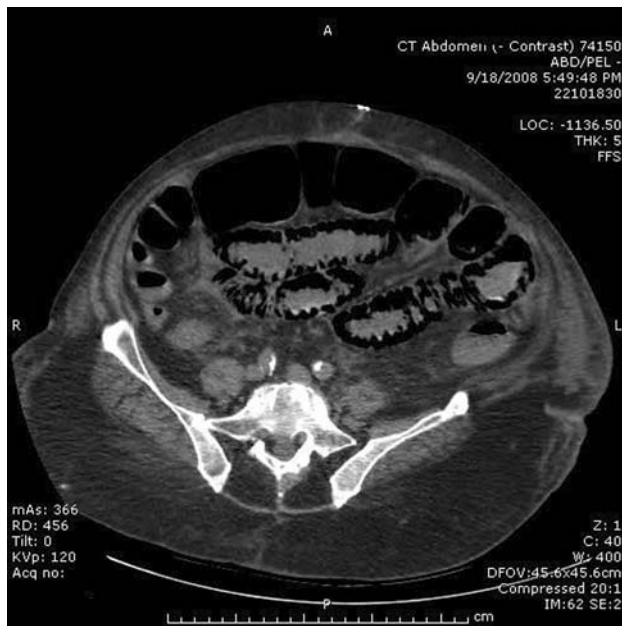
Pneumatosis intestinalis seen on abdominal CT scan
